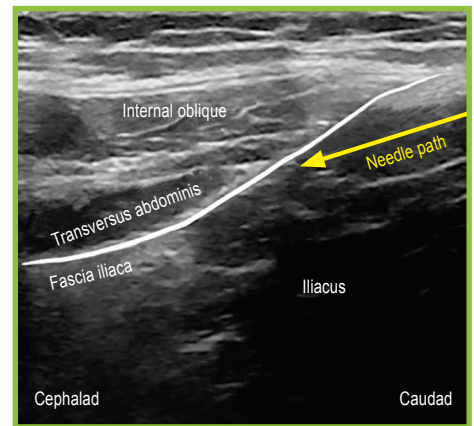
Fascia iliaca field block ultrasound.
